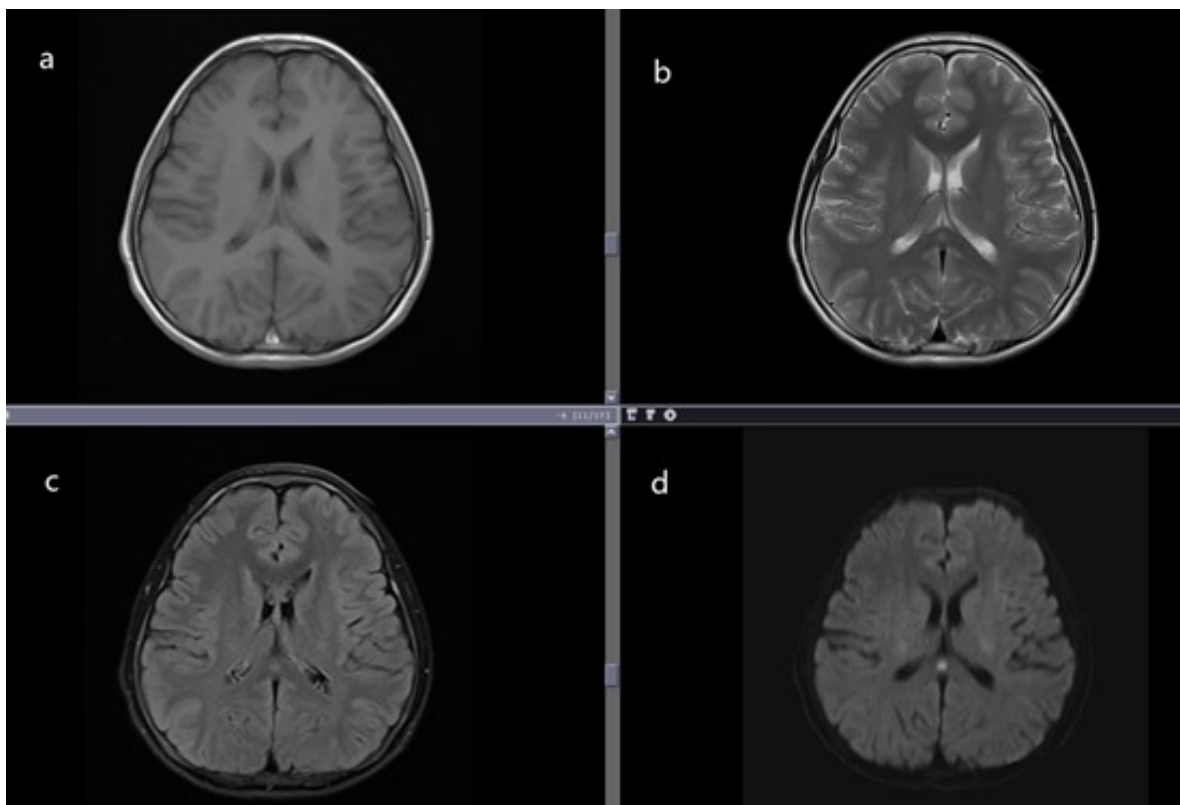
The brain MRI showed slight hypointense on T1WI (Fig. 1a). T2WI (Fig. 1b), FLAIR(Fig. 1c) and DWI(Fig. 1d) show high signal lesions in the splenium of the corpus callosum .
